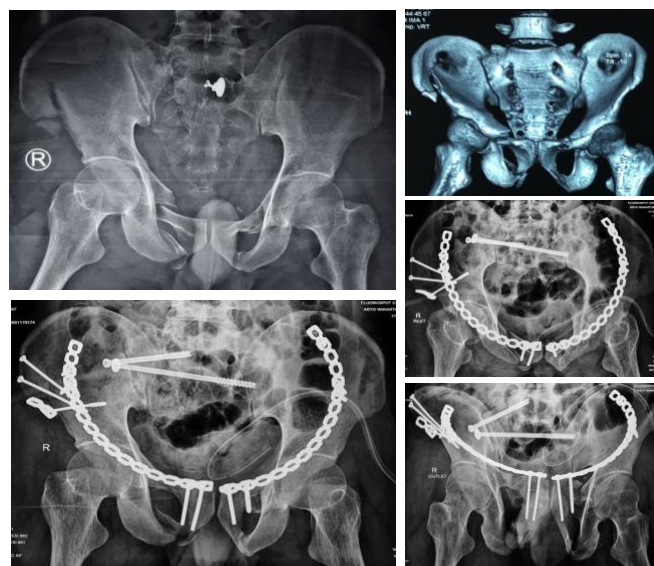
32 years old male with sacral dysmorphism. The initial x-ray showed right SI Joint disruption, right iliac wing fracture, and bilateral pubic rami fracture. Treatment strategies consist of minimal invasive ORIF of bilateral pubic rami, fixation of the ilium through a lateral window and iliosacral screw fixation for the SI joint. CT Scan is mandatory to plan screw trajectory in sacral dysmorphism
